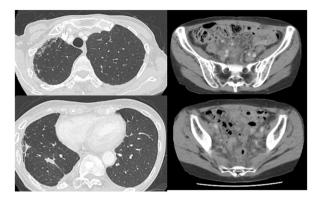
On chest CT, the right lower lobe had been resected and showed right pleural thickening. Abdominal CT showed enlarged lymph nodes in the region of bilateral iliac arteries and peritoneal dissemination.
